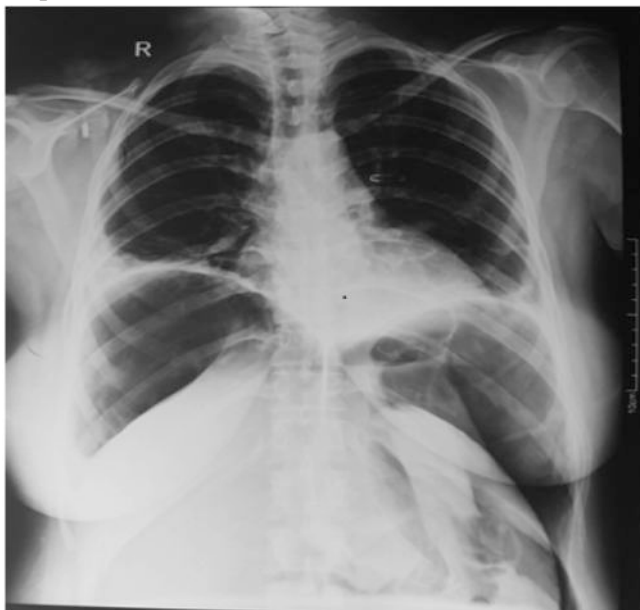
Chest x-ray PA view
